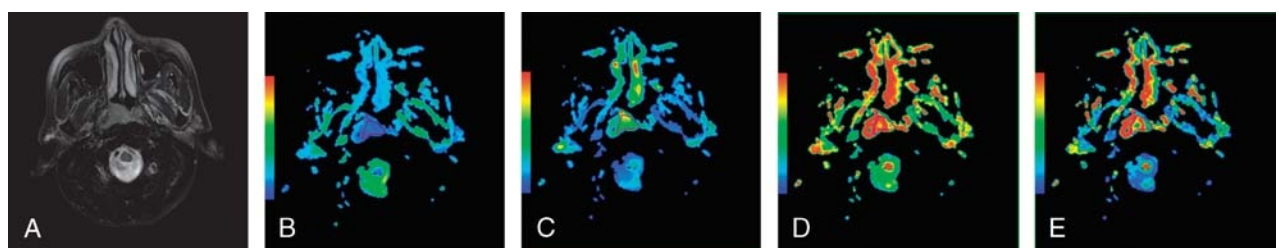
Representative images of NPC. Images 1A to 1E are axial T2-weighted images, ADC, *D*, *D, and *f* maps, respectively. The ADC, *D*, *D, and *f* values of the lesion were 0.890×10^{-3} , 0.669×10^{-3} , 13.426×10^{-3} mm²/s, and 0.153, respectively.
